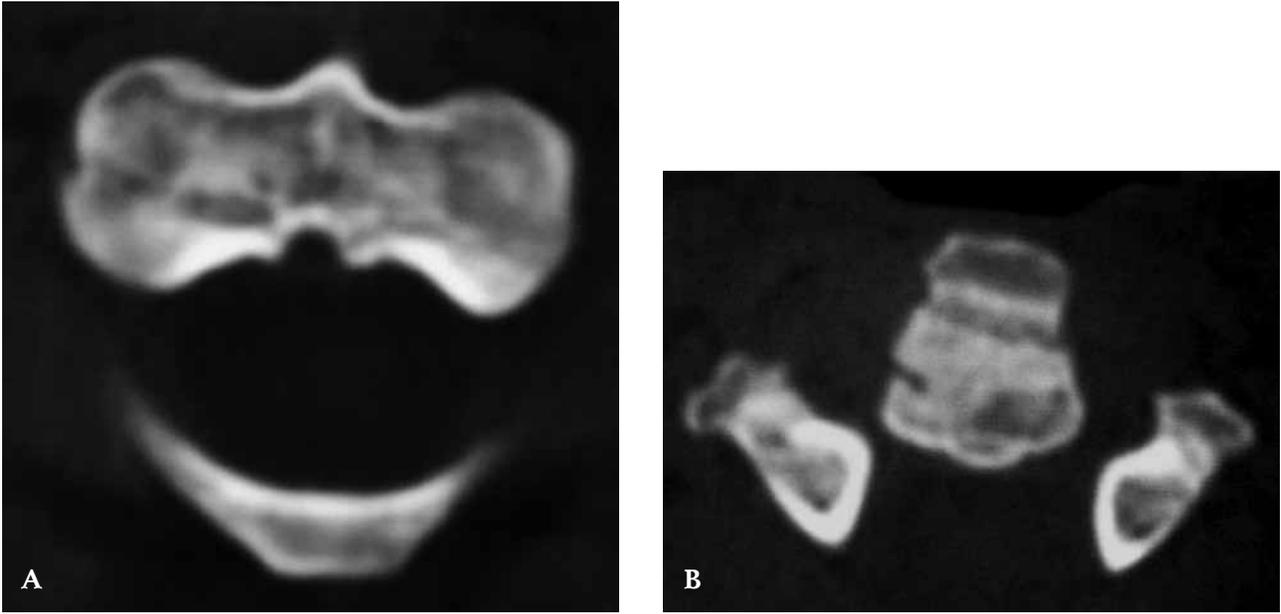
A-B: Bone fusion is seen at coronal fracture and teardrop fracture at control CT performed after sixteen months.
